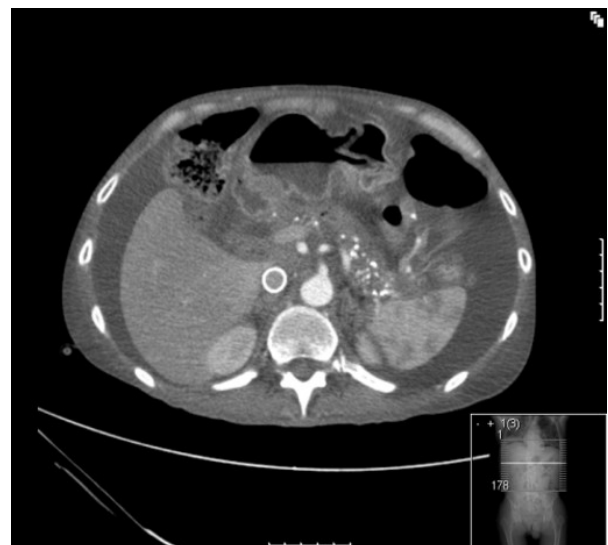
CT scan done at 2 months showing complete resolution of pancreatic lesion and showing a metallic stent in place in the inferior vena cava.
